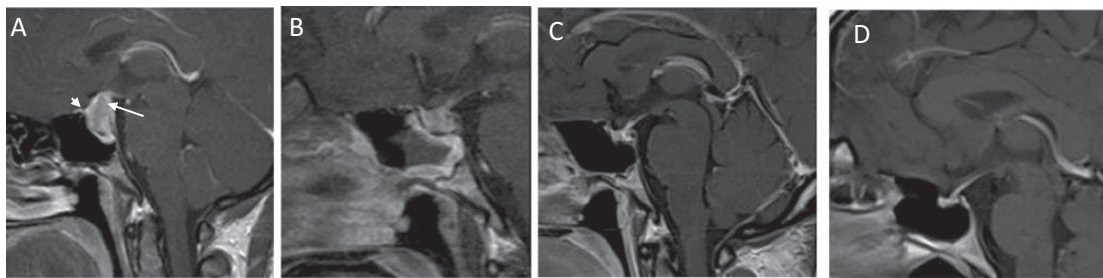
Sagittal postcontrast T1W MR images of the pituitary. A: Pretreatment scan showing an enlarged and diffusely enhancing pituitary gland extending into the suprasellar cistern (long white arrow) with adjacent dural enhancement (short white arrow). B: Image following GC and RTX treatment showing the initial response to treatment with significant reduction in the size of the pituitary mass. C: Image following further RTX treatment showing substantial reduction in the size of the pituitary mass. D: Image following treatment with Ofatumumab, demonstrating full normalization of the pituitary gland.
